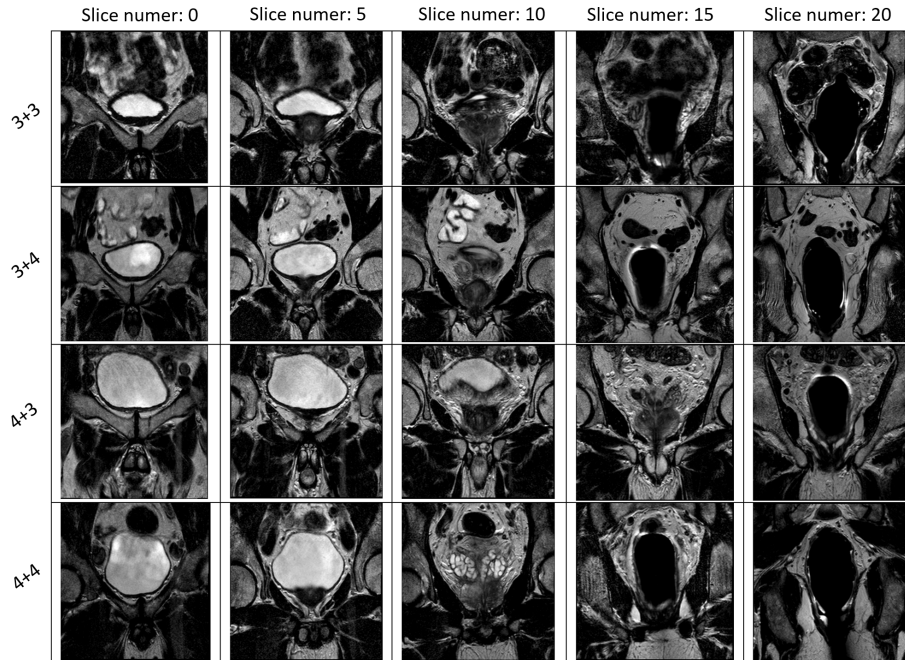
An example of MRI slices belonging to the analysed data-set.
